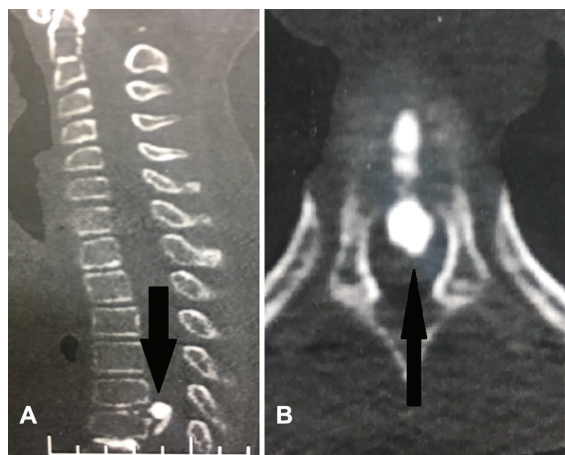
The spinal CT scan of the central calcified disc herniation. (A) Sagittal plane, (B) Axial plane.
